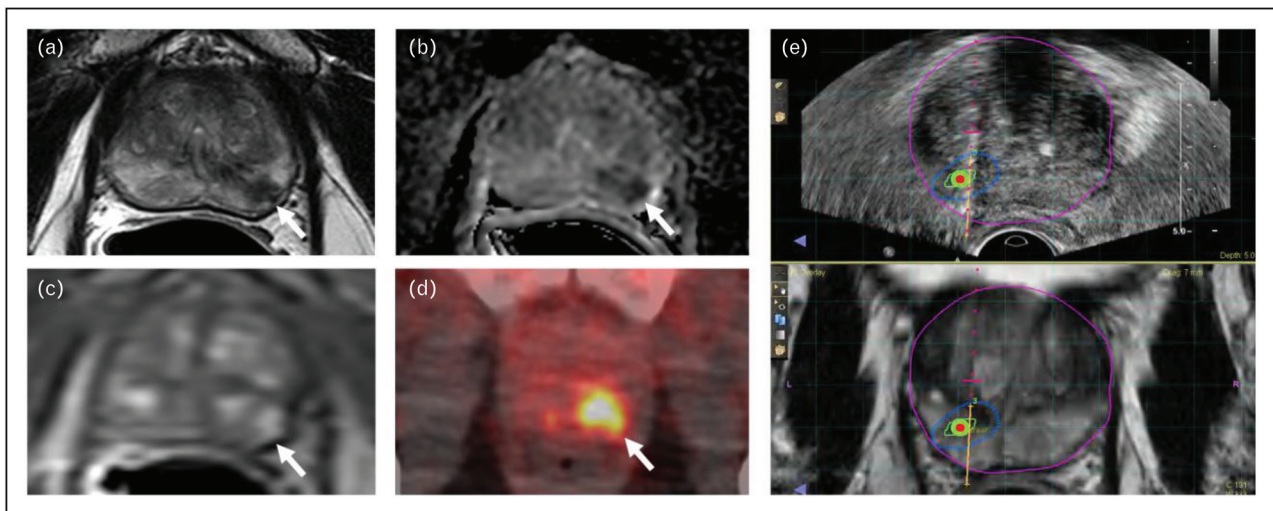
73-year-old male with a serum PSA of 4.74ng/ml. Axial T2W MRI shows a heterogeneous hypointense lesion in the left apical-mid peripheral zone (arrow) (a), which shows diffusion restriction on ADC map (arrow) (b) and early enhancement on DCE MRI (arrow) (c). ^{18}F -DCFPyL PET/CT demonstrates focal tracer uptake within the left apical-mid peripheral zone lesion (arrow) (d). TRUS/MRI fusion guided biopsy revealed Gleason 4+4 prostate cancer within this lesion (e). MRI, magnetic resonance imaging; TRUS, transrectal ultrasound.
